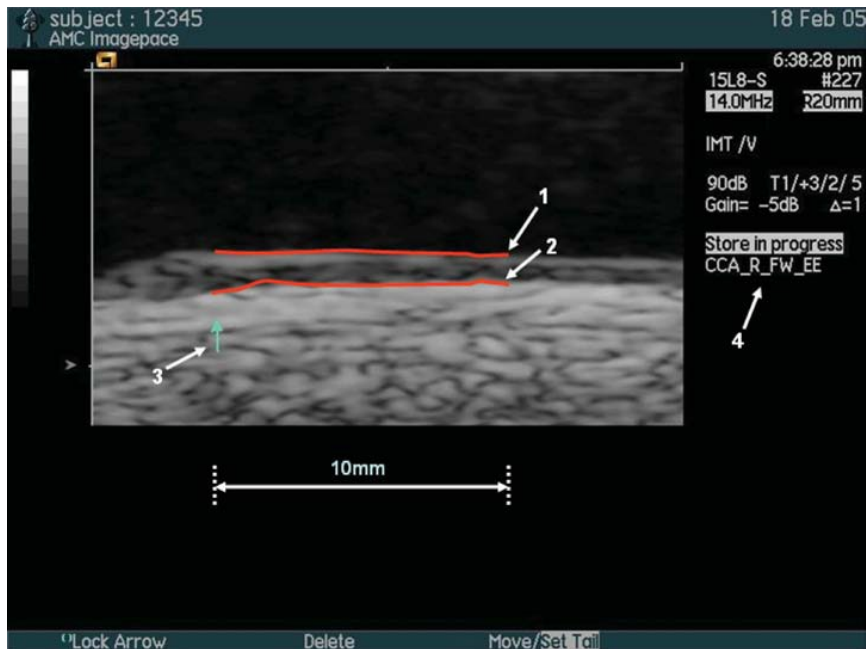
B-mode ultrasound image of the carotid intima media thickness. Line 1 indicates the lumen-intima interface and line 2 indicates the media-adventitia interface.
